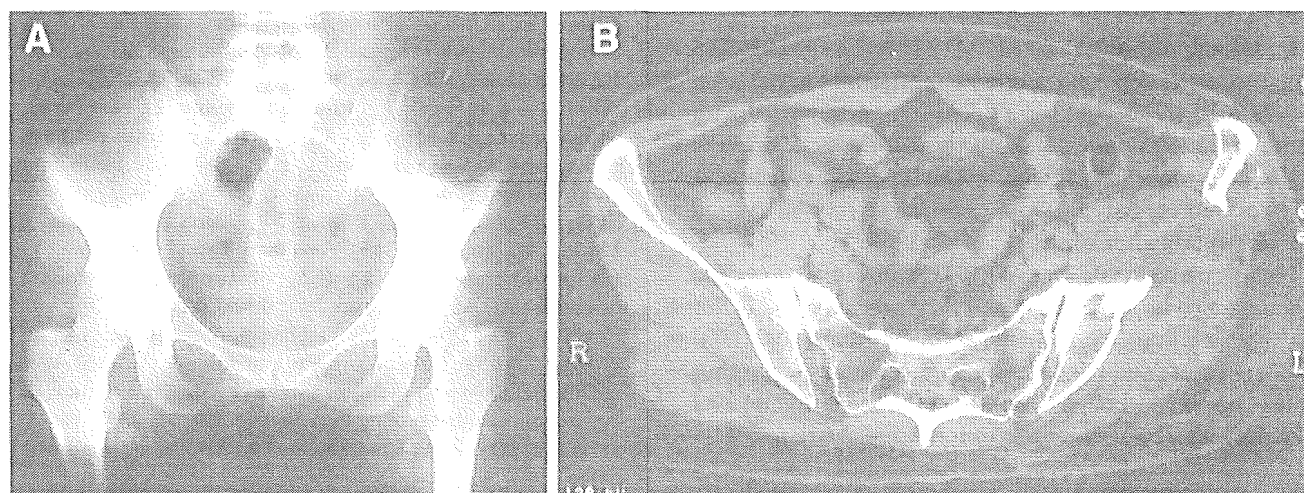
Postoperative plain X-ray (A) and CT (B) of Case 9 at 24 months after AO-PDT with AO-RDT. There is no evidence of local tumor recurrence around the illium.
